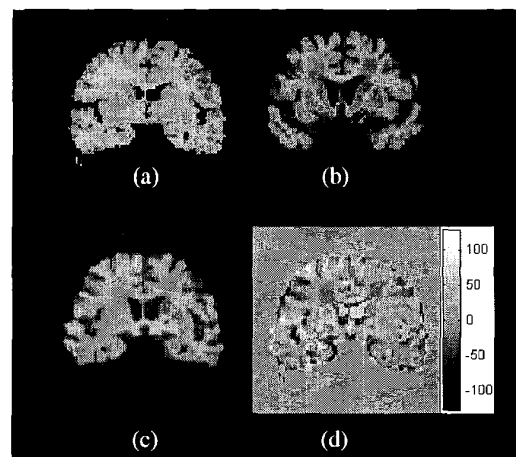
Results of coronal image registration using 2nd-order polynomial transformation. (a) A postmortem image (b) initial MRI for iterative registration (c) registered MRI, and (d) difference between postmortem and registered MR image, i.e., (c) minus (a). The gray-scale bar indicates positive and negative values in the difference image.
